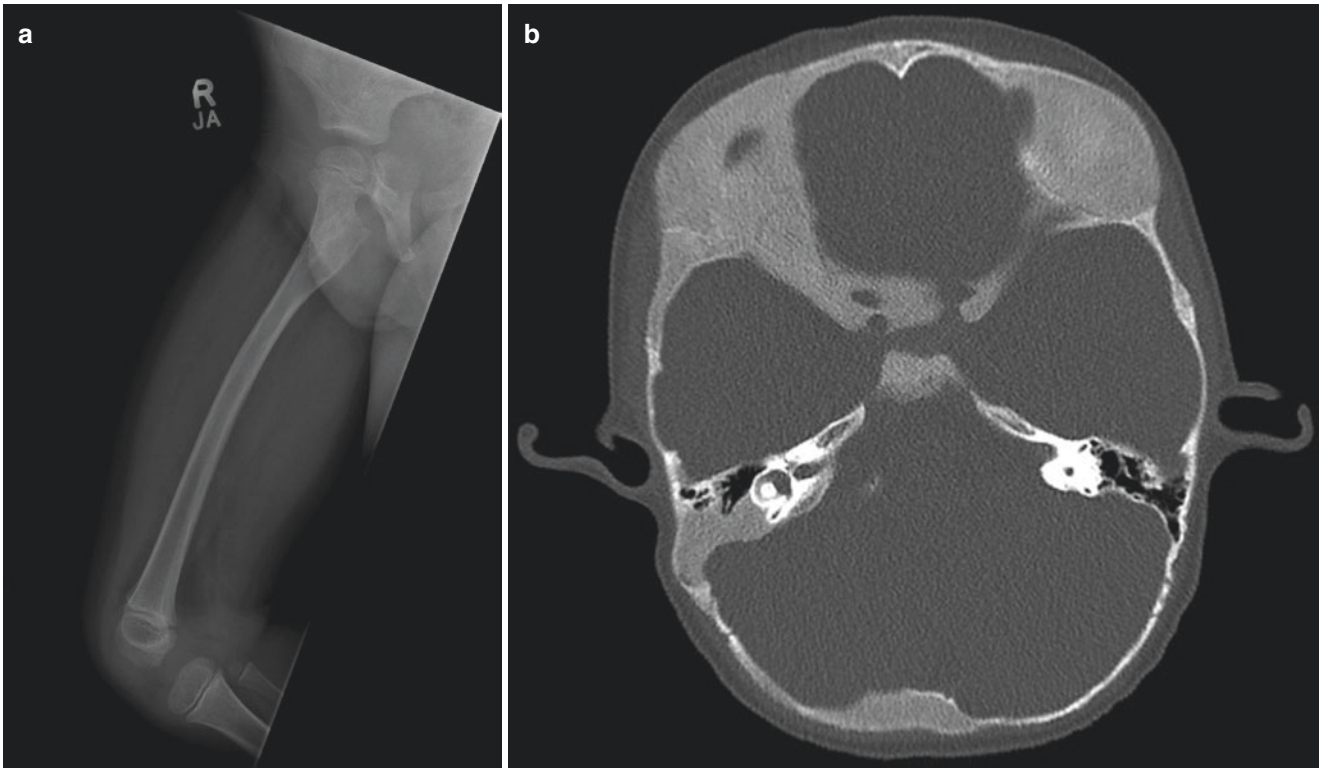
(a and b) Frontal X-ray of the right femur and axial CT scan of the skull at the level of temporal bones reveal presence of multiple expansile lesions with ground glass matrix in keeping with fibrous dysplasia
